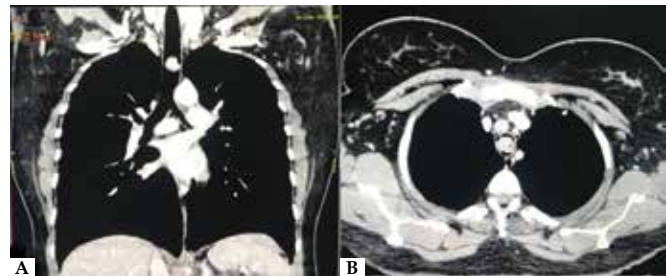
Computed tomography of the chest (coronal and axial view) showing tracheal tumour obliterating >95% of its lumen.
